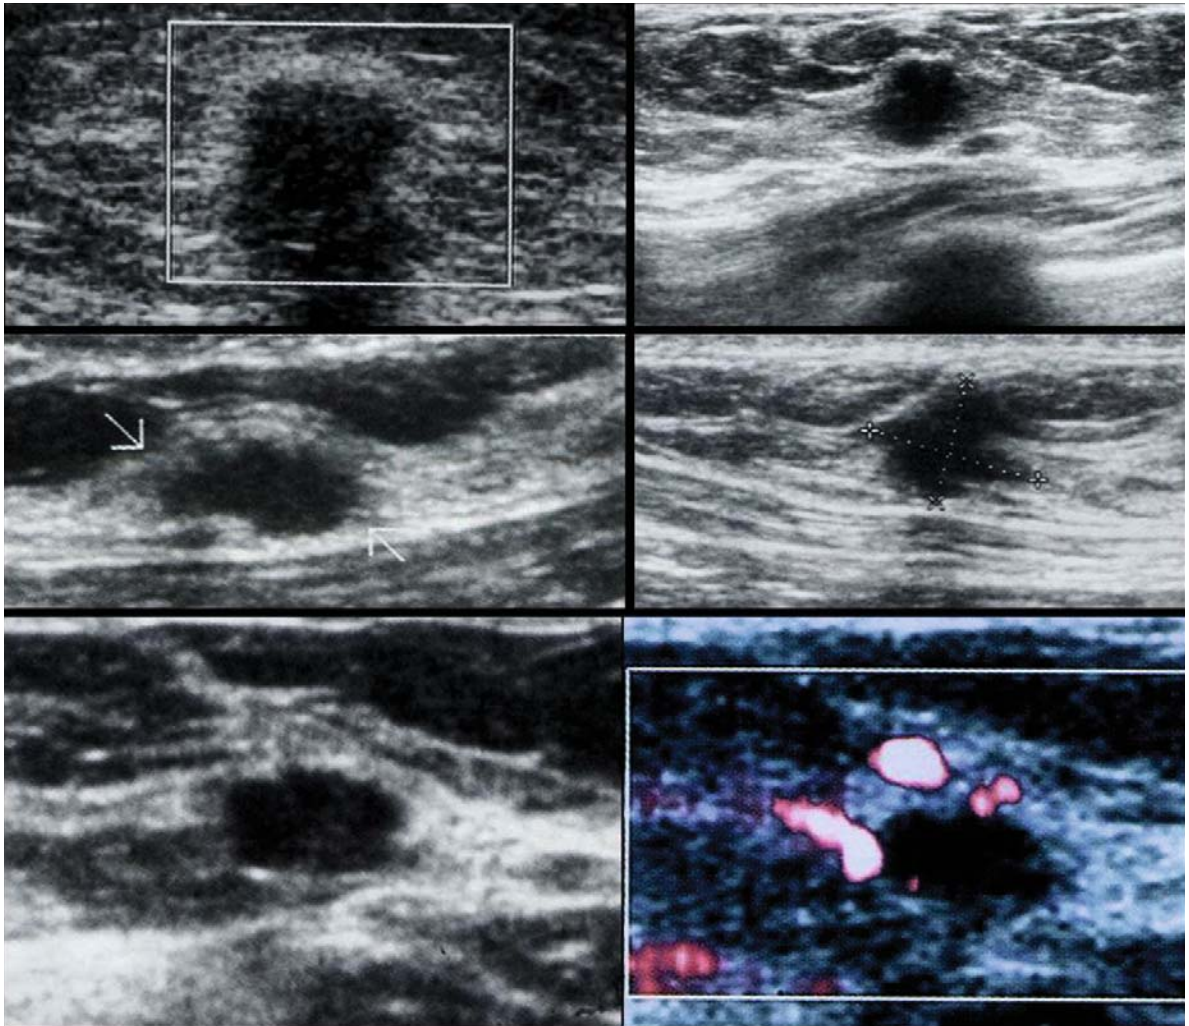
Conventional B-mode ultrasound: findings of lesions highly suggestive of malignancy
